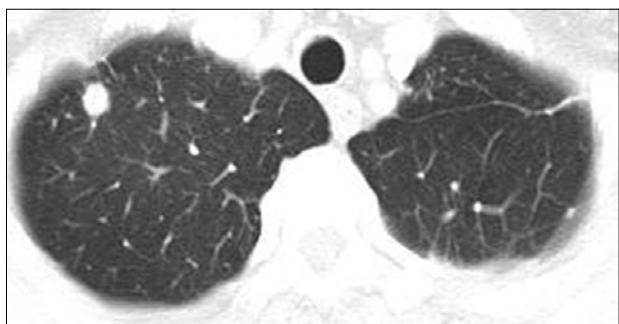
Chest CT shows a round opacity in the right upper lobe.
